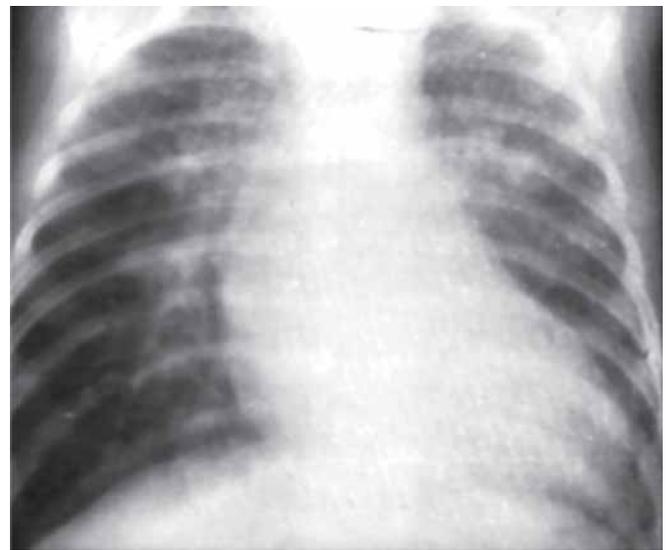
Chest radiograph of a newborn with transposition of great arteries (egg-on-side)
